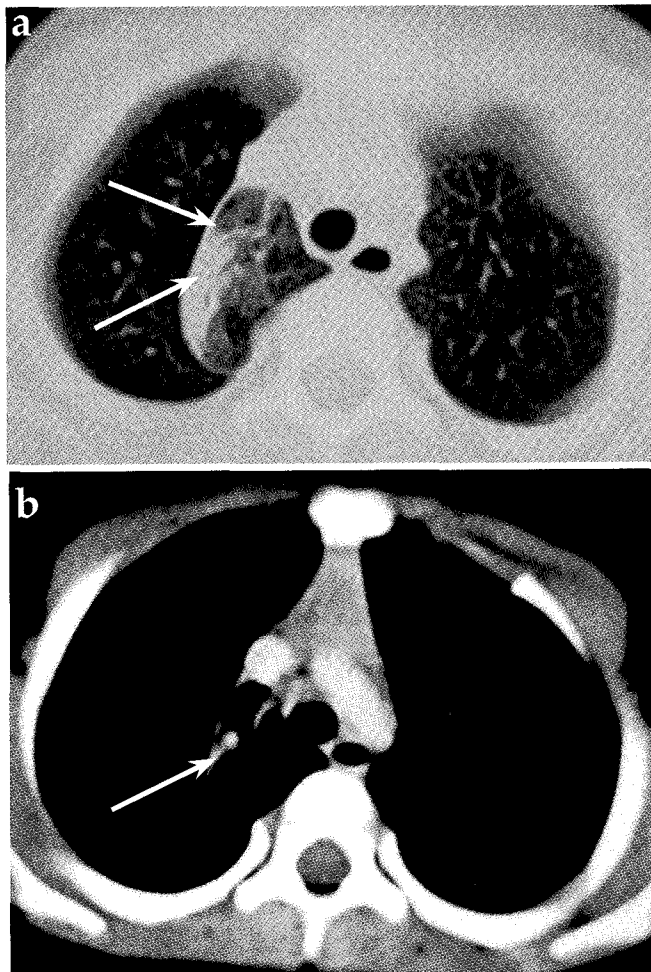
(a) CT scan: The airspace opacity (arrows) involving part of the azygos lobe is bound by the outwardly convex azygos fissure. (b) Mediastinal window demonstrates the azygos fissure extending from the superior vena cava anteriorly (arrow), but does not demonstrate any mediastinal mass.
